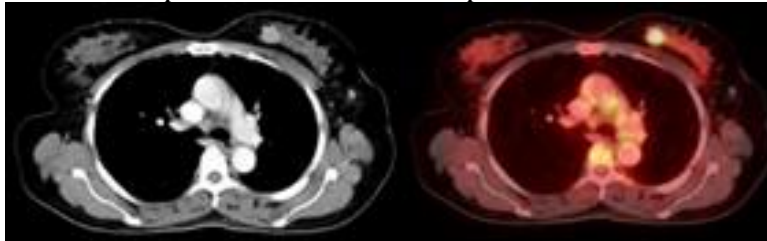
CECT image of chest on the left, showing heterogeneously enhancing ill-defined mass lesion of left breast and right- side image of PET-CECT thorax, showing FDG avid primary left breast invasive ductal carcinoma.
